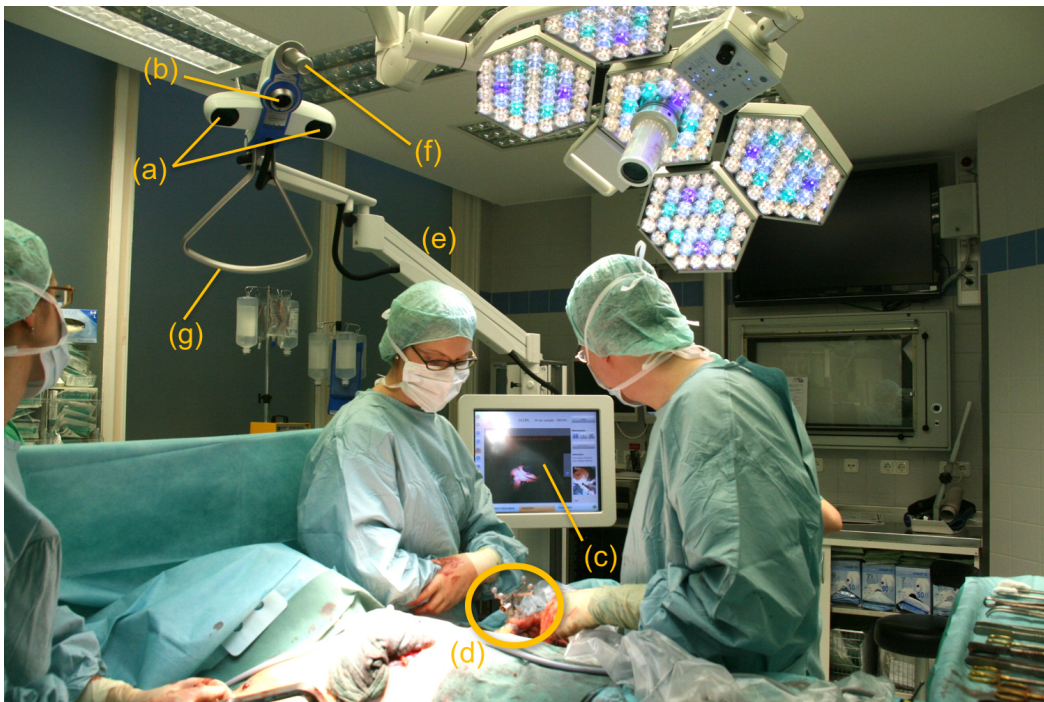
Freehand SPECT device in the operating room. (a) Infrared tracking cameras. (b) video camera for AR visualization. (c) Touch-screen monitor for visualization and user interaction. (d) Gamma probe in a sterile foil and sterile tracking probe in a sterile target attached. (e) Positioning arm. (f) Sterile handle. (g) Unsterile handle.
